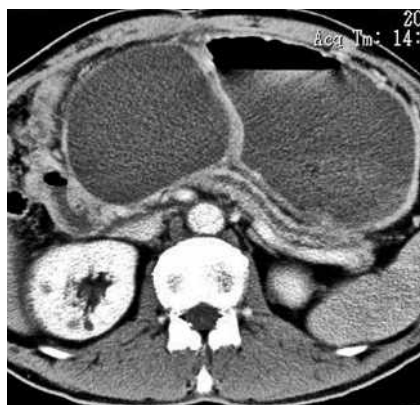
Computed tomographic view showing a pancreatic pseudocyst that developed 3 months after the surgical resection and pancreaticogastrostomy.
